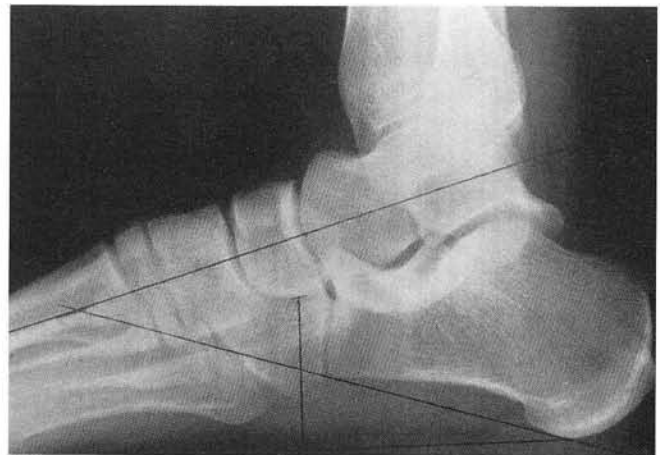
Lateral neutral position radiograph. Total restoration of alignment has been achieved. This is the desired position of fusion for this patient.
